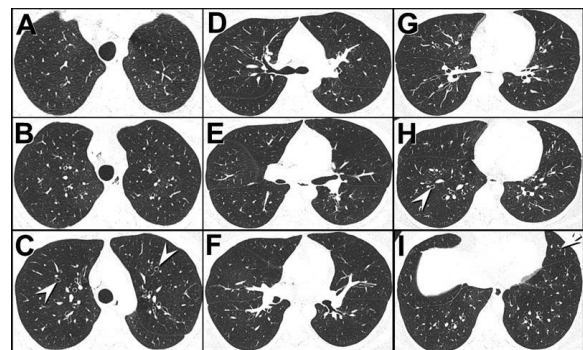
Axial unenhanced inspiratory HRCT images through the upper (A-C), mid (D-F) and lower (G-I) lungs. Click [here](#) to view Figure 9 in a separate, enlarged window. Click [here](#) to view a video of Figure 9.
